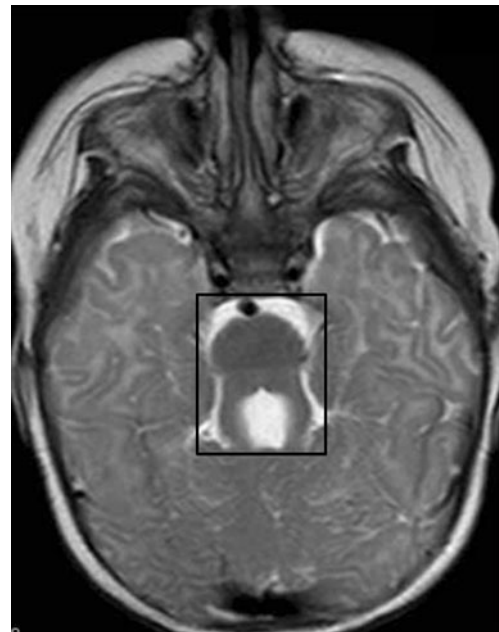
Brain magnetic resonance imaging (MRI) axial image at the level of the superior cerebellar peduncles of a Joubert syndrome (JS) patient. The “molar tooth sign” (boxed) is a classical neuroradiological characteristic of JS and is characterized by cerebellar vermis aplasia, thickened and elongated superior cerebellar peduncles, and a deepened interpeduncular fossa
